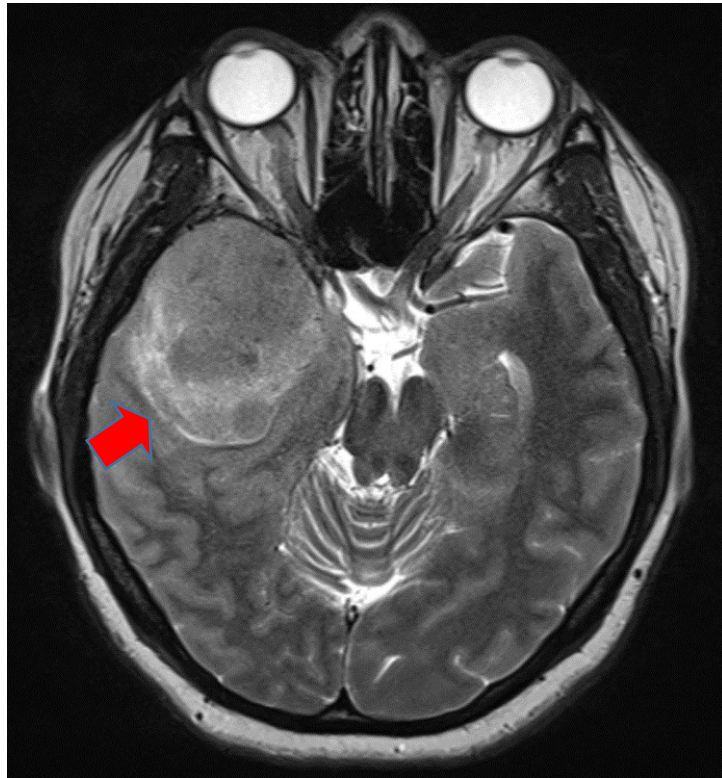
Axial view of T1-weighted MRI imaging showing well circumscribed extra-axial mass at the right middle cranial fossa measuring 5.4cm x 5.6cm x 6.3cm (AP x W x CC). There is midline shift to the left with uncus herniation and displacement of the right middle cerebral artery and midbrain. Bilateral globes are normal with no optic nerve compression.
